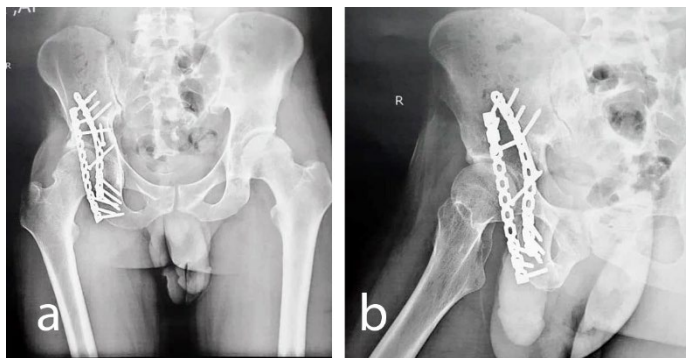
AP (a) and oblique (b) X-rays four years after the surgery
